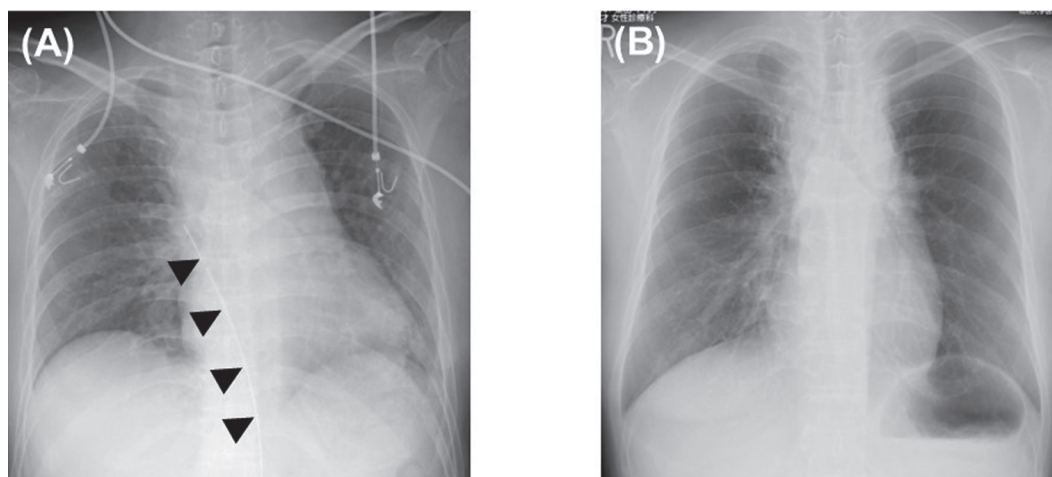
Chest radiographs. (A) Scan taken immediately after pericardial fenestration and pericardial drainage. \blacktriangle indicates the drainage tube. (B) Two months later.
